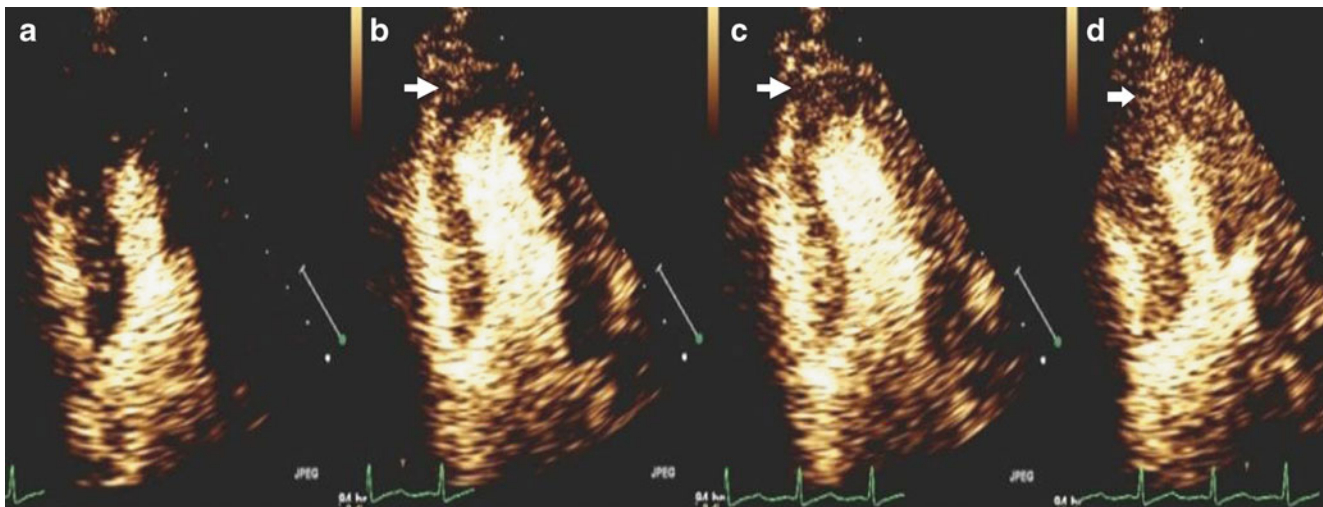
Apical perfusion defect (*arrows*) visualised on contrast myocardial echocardiography. In the apical myocardium vascularised by a stenotic coronary artery the rate of refilling is slower (a–d) in comparison to the other myocardial regions (courtesy from doctor Gaibazzi, Parma)
